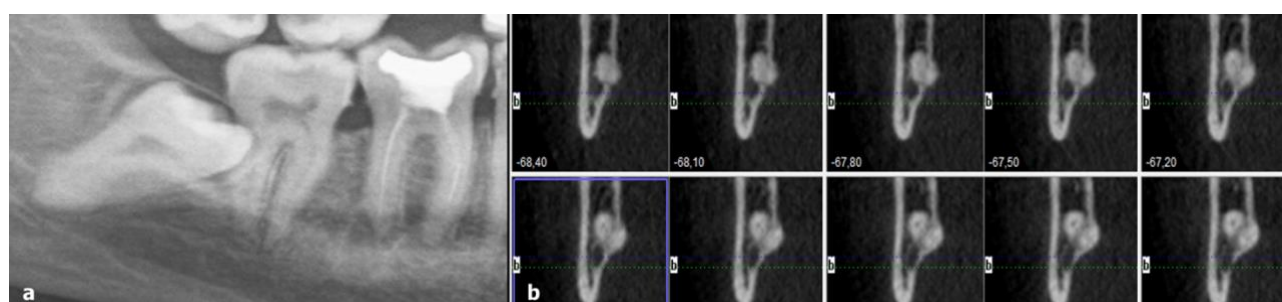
Relationship of ILTM root no. 48 with the lingual cortical bone. (a) PR images of tooth no. 48 (there is an interruption in the white line of the IAC), (b) Cross-sectional images of tooth no. 48 on CBCT (lingual bone perforation).
